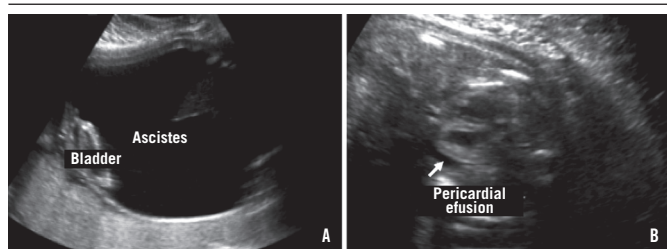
25-weeks ultrasound scan images showing severe ascites (A) and pericardial effusion (B) (see white arrows)
